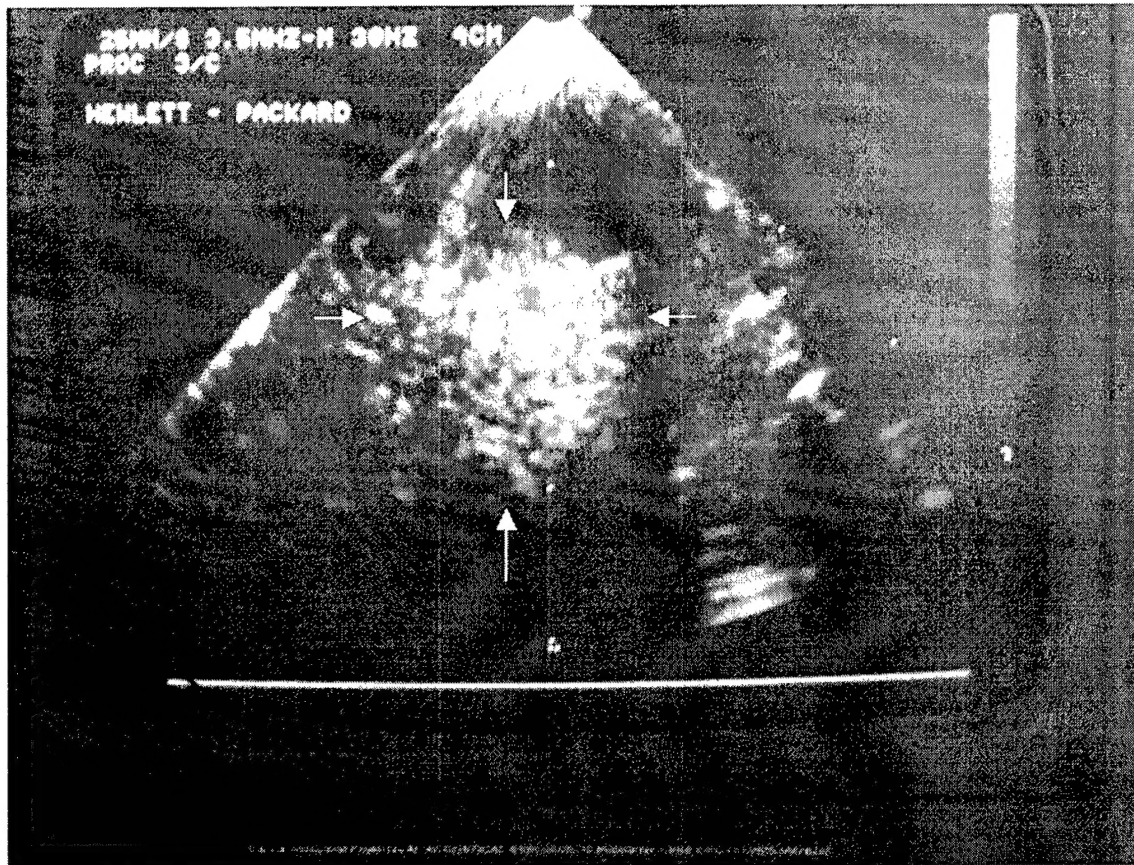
Ultrasound B-scan of the excised tumor pointed by arrows. Tumor was imbedded in the intralipid of approximately 0.7% concentration and the fitted background  $\mu_a$  and  $\mu_s'$  values are 0.021  $\text{cm}^{-1}$  and 6.83  $\text{cm}^{-1}$ , respectively.
